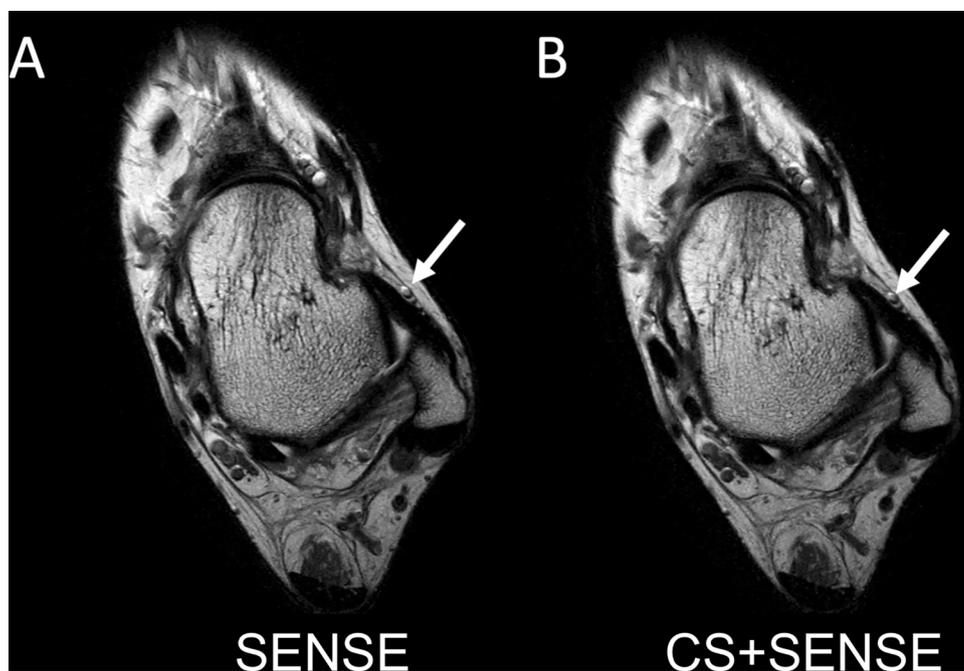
Axial T2-weighted images acquired with SENSE only (A) and acquired with the combination of CS and SENSE (CS + SENSE; B) showing the ankle of a 28-year-old male volunteer with thickening of the anterior talofibular ligament (white arrows). The quality of the depiction of the ligaments were rated equally on both images by both readers.
